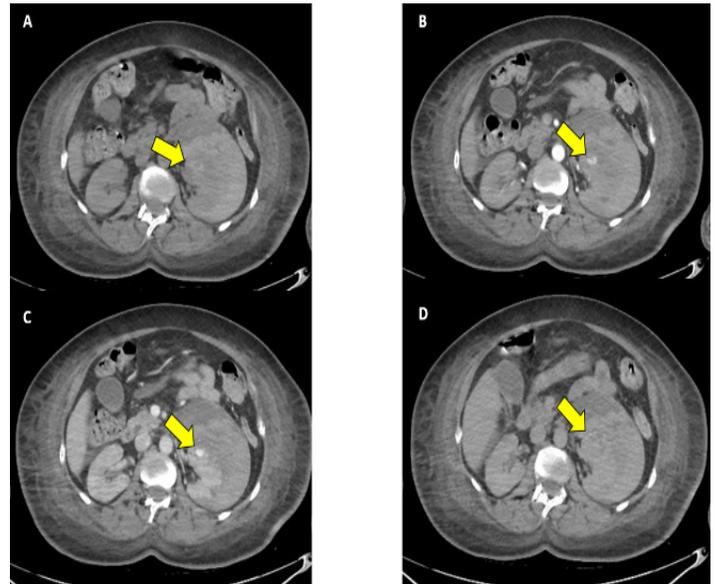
Contrast-enhanced abdominal computed tomography in the axial plane showing a large left perirenal hematoma (A) with evidence of active bleeding better visualized in the arterial phase (B) and portal phase (C). Excretory-phase image, after 10 minutes of acquisition (D), showing absence of contrast medium clearance, thus confirming nephropathy. Yellow arrows indicate the focus of active bleeding from the ruptured pseudoaneurysm.
